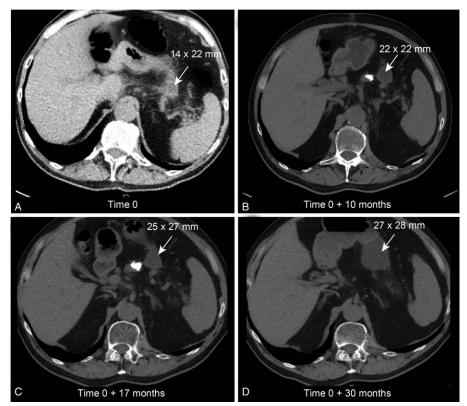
Patient #3—An incidentally diagnosed intramural gastric pseudocyst, The identification of the pseudocyst was determined in retrospect by reevaluation of the CT imaging during follow-up of a nonsymptomatic patient after previous curative treatment for renal cell carcinoma. (A) The first available CT examination; white arrow indicates the intramural pseudocyst; (B) 10 months later; only minor cystic growth; (C) slight expansion after another 7 months; (D) the most recent CT performed 30 months after the first CT (see [A]) shows a continuous and slow growth pattern. The patient remains asymptomatic and progression-free of his right RCC. CT=computer tomography, RCC=renal cell carcinoma.
